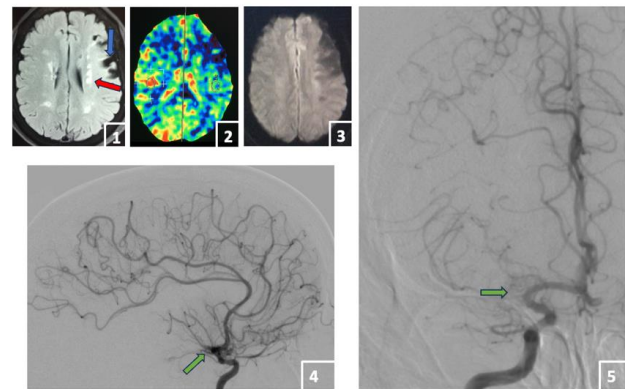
Case 1. Image 1: Axial brain MRI, T2 FLAIR sequence, showing an ischemic stroke in the left frontal area (blue arrow), with hypersignal paraventricular lesions indicating white matter ischemia at junctional zones (red arrow). Image 2: Perfusion MRI showing hypoperfusion and decreased CBV in the penumbra regions. Image 3: Diffusion MRI showing an ischemic stroke in the left frontal region. Image 4: Lateral cerebral angiography showing absence of an MCA trunk with a plexiform vessel network of small arteries (green arrow), and a normal carotid and anterior cerebral artery. Image 5: Frontal cerebral angiography showing no discontinuity in the carotid artery and absence of the MCA, replaced by a mildly dense plexiform vessel network (green arrow), with poor cortical perfusion in the inferior parietal area.
